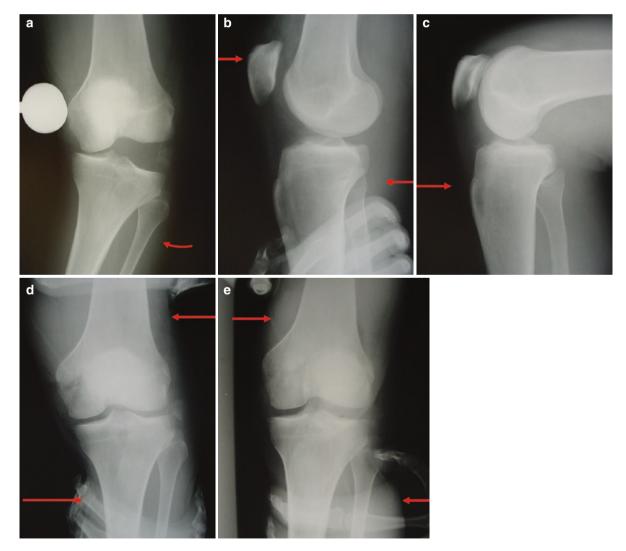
Stress x-rays identify a lateral bicruciate lesion and exclude a dislocation. Varus stress view reveals laxity of the lateral structures (a). Although anterior and posterior stress lateral x-rays reveal bicruciate
